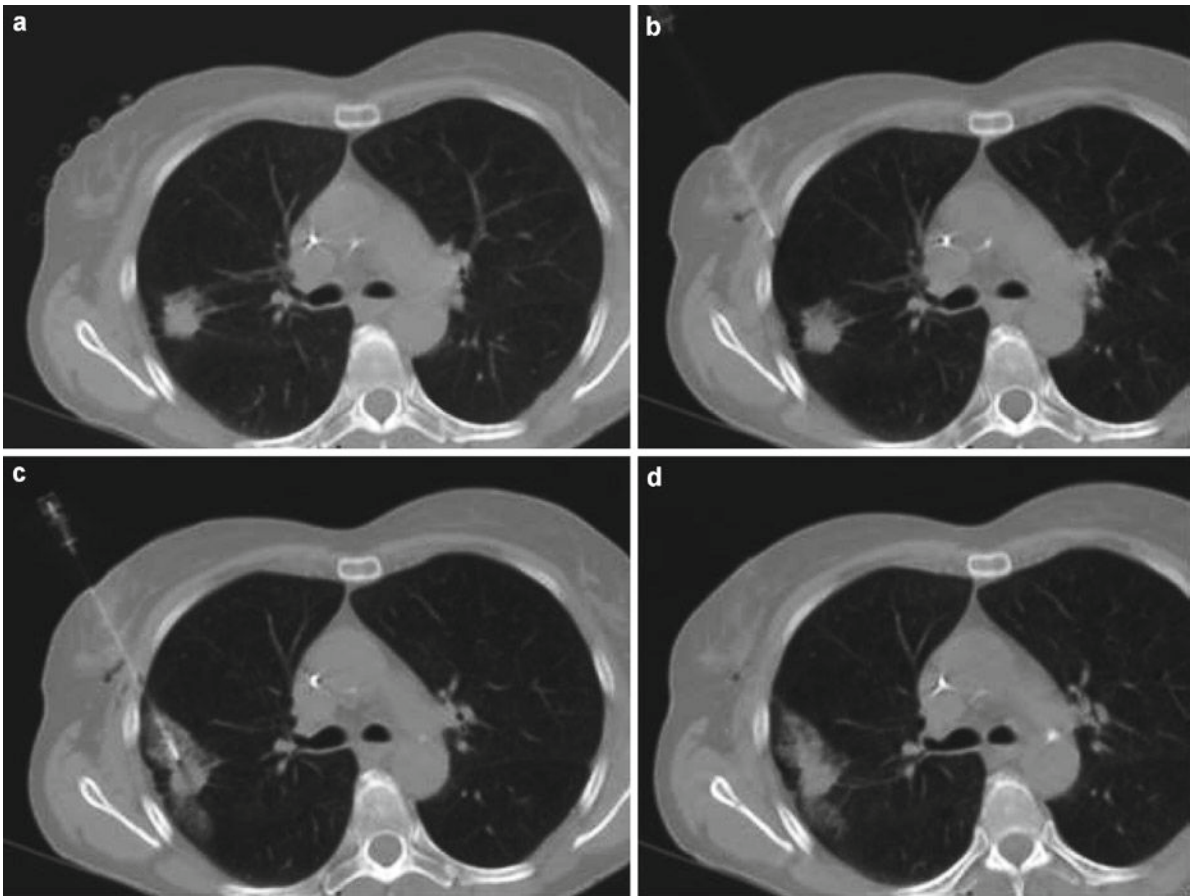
CT-guided lung biopsy in a 63-year-old patient with a history of non-Hodgkin's lymphoma and a suspected pulmonary relapse. The biopsy unexpectedly showed an adenocarcinoma
